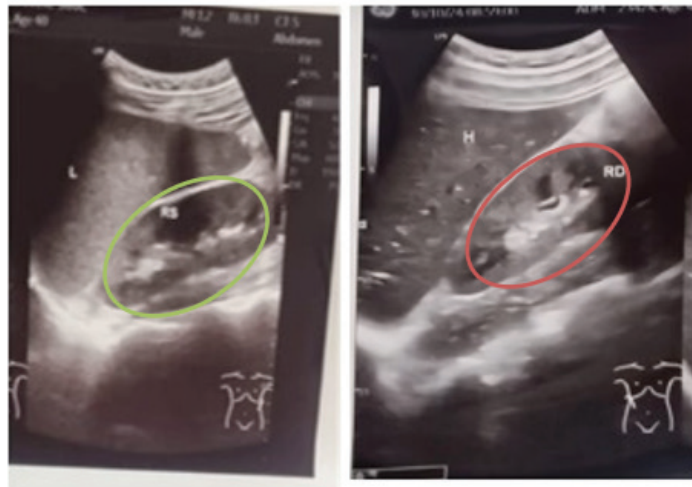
Abdominal Ultrasound on 10 March 2025. Both Kidneys Show Normal Size and Echotexture, And Normal Morphology Does Not Rule Out Functional Acute Kidney Injury
